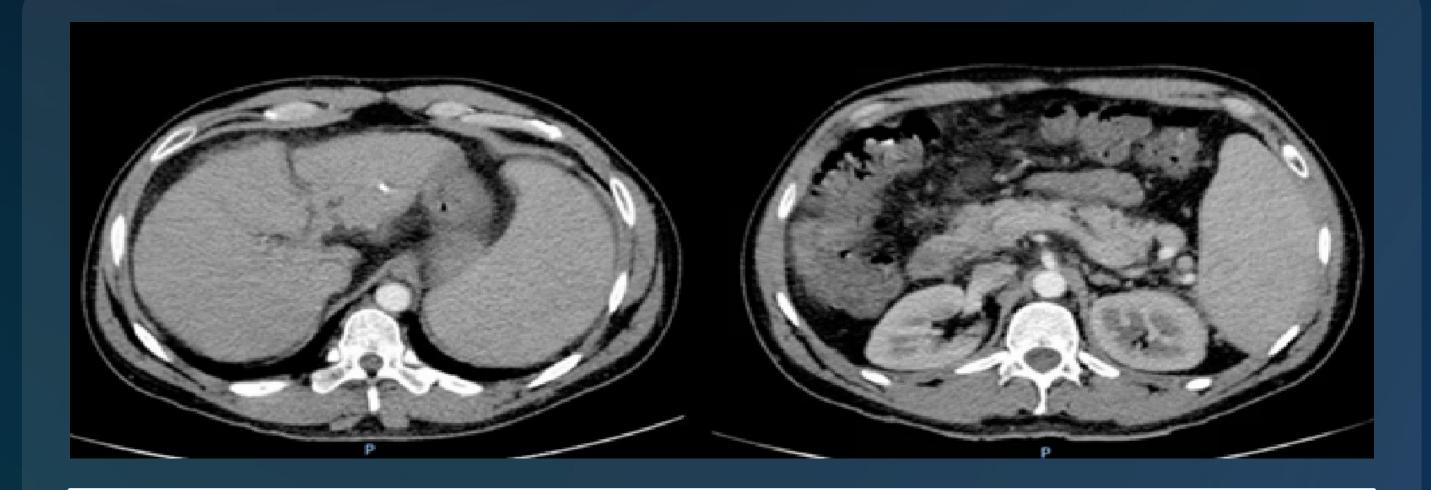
Abdominopelvic CT scan with IV contrast demonstrating splenomegaly, free peritoneal fluid, colonic thickening, edema, and fat stranding
